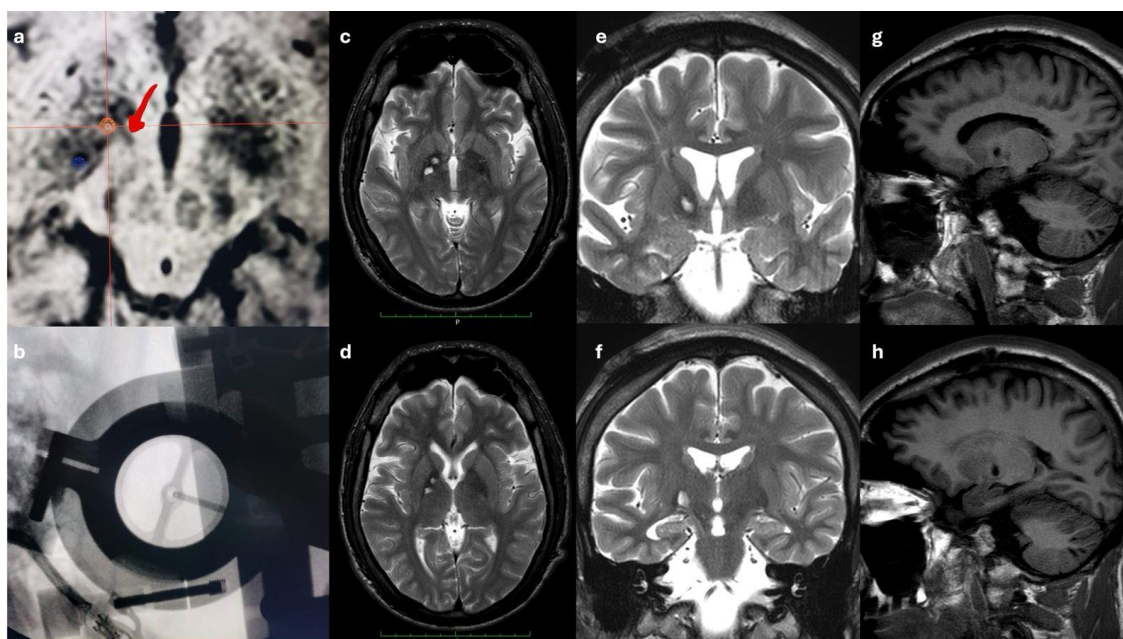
Pre- and postoperative imaging. a) preoperative planning depicting the targeted region of interest within the anteromedial (am) (red) and posteroventral (pv) (blue) right Globus pallidus internus (GPI), where the Ansa Subthalamica, which connects the limbic areas of the subthalamic nucleus the GPI, is also seen (red arrow). b) intraoperative lateral x-ray showing the radiofrequency electrode at target. T2-weighted postoperative MRI scans revealing the am- and pv-GPI pallidotomies in axial (c and d) and coronal views (e and f), respectively. T1-weighted postoperative sagittal MRI scans revealing the am- (g) and pv-GPI (h) pallidotomies.
